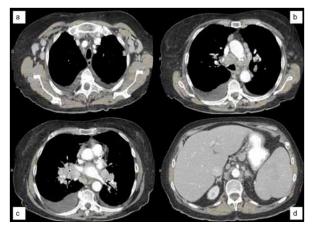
Initial axial contrast-enhanced computed tomography images demonstrating (a) axillary, (b) mediastinal, and (c) hilar lymphadenopathy, as well as (d) splenomegaly.
